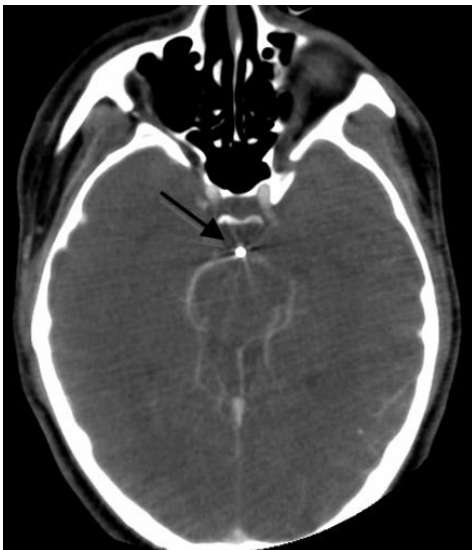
Contrast enhanced CT angiogram of the head demonstrating a radiopaque foreign body (arrow) in the expected location of the basilar artery with enhancement of the posterior cerebral arteries.
